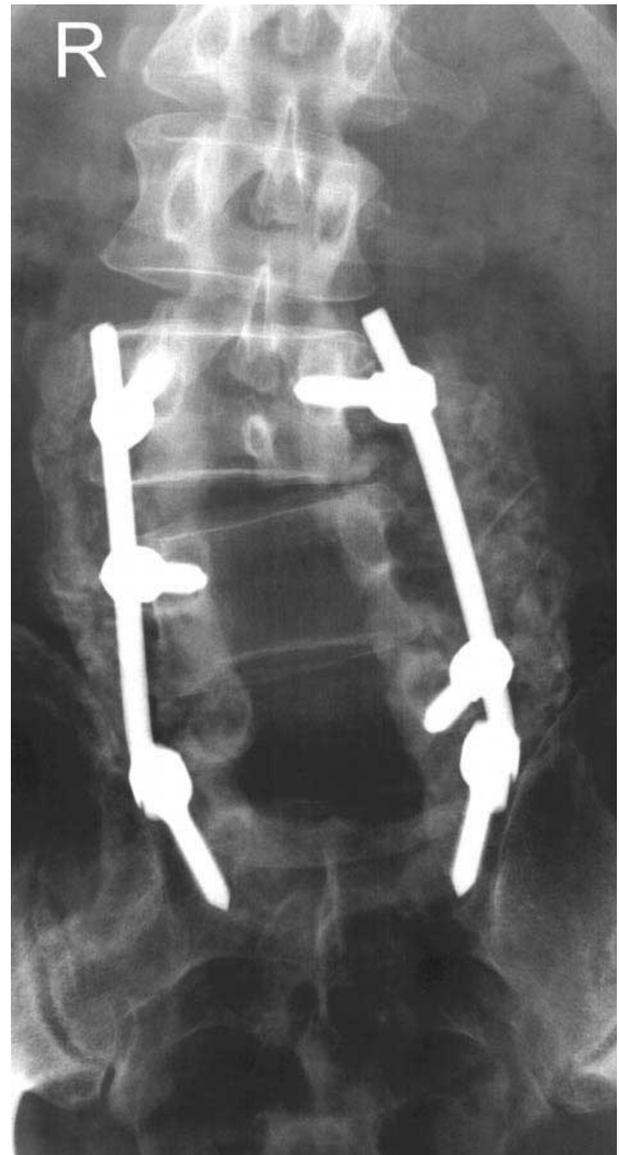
Antero-posterior radiograph of a patient who has undergone L_{3-S1} fusion with pedicle screw and posterior rod instrumentation and autologous bone graft and posterior decompression with removal of the spinous processes and lamina of L₄ and L₅. Surgical screws extend through the axis of the pedicles into the vertebral bodies. Pedicle screws are in place on the left at the L₃, L₅, and S₁ levels and on the right at the L₃, L₄, and S₁ levels. A fusion mass of autologous bone extends from the transverse process of L₃ to the sacral ala bilaterally.
